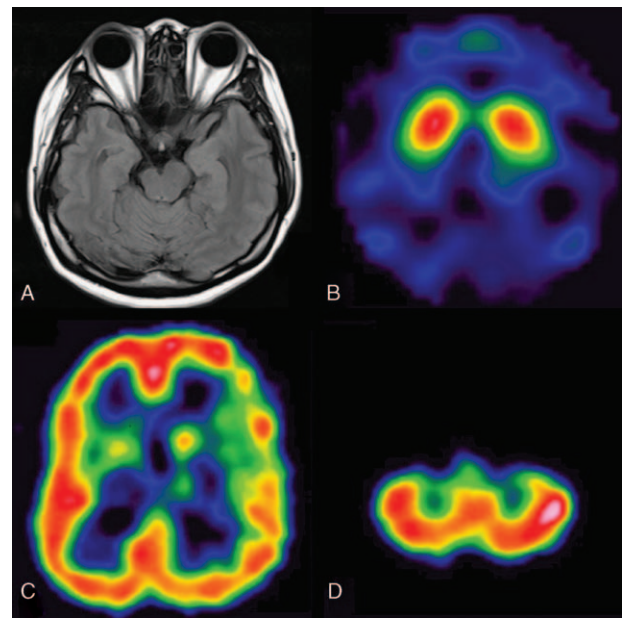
Various images of the patient. Axial brain fluid-attenuated inversion recovery MRI shows small size of the right midbrain (A). Axial 99mTc TRODAT-1 brain scan shows no obvious secondary reduction in the expression of dopamine transporter of the caudate nucleus and putamen (B). Axial brain perfusion SPECT with 99mTc-ECD revealed hypometabolic change over the left fronto-parietal regions, left anterior temporal region, and left occipital, left striatum and right cerebellum in the serial images (C, D). 99mTc TRODAT-1 = Technetium-99m-labeled tropanes as dopamine transporter imaging agents, ECD = ethylene cysteine diethyl ester, MRI = magnetic resonance imaging, SPECT = single-photon emission computed tomography.
